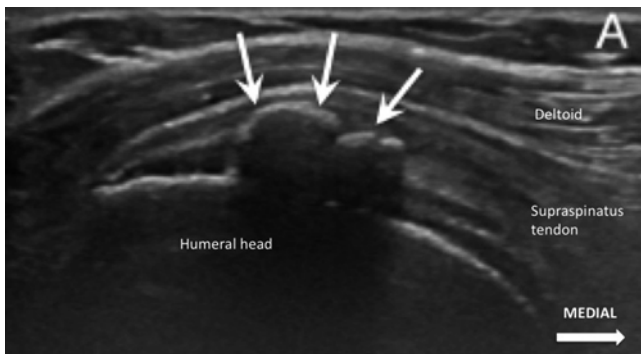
Sonography of the calcium deposit in hard calcific phase. The *arrows* indicate the calcification. Note the anechoic shadow cast by the calcium (Reproduced with permission from Philip Peng Educational Series)
